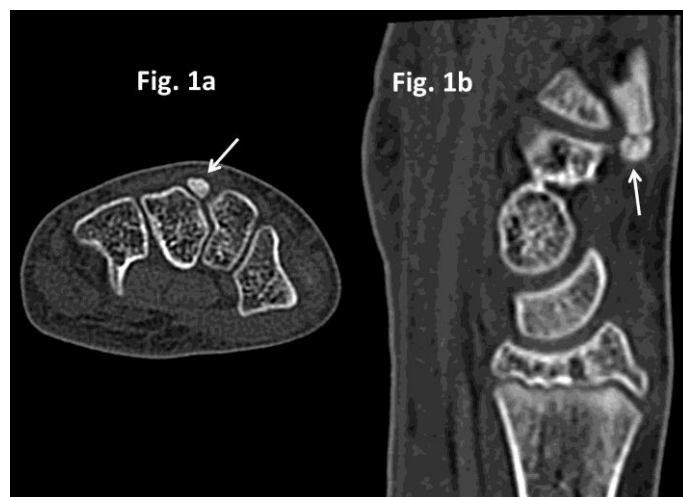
15-year-old male patient with symptomatic os styloideum (Non-enhanced CT of the wrist)
